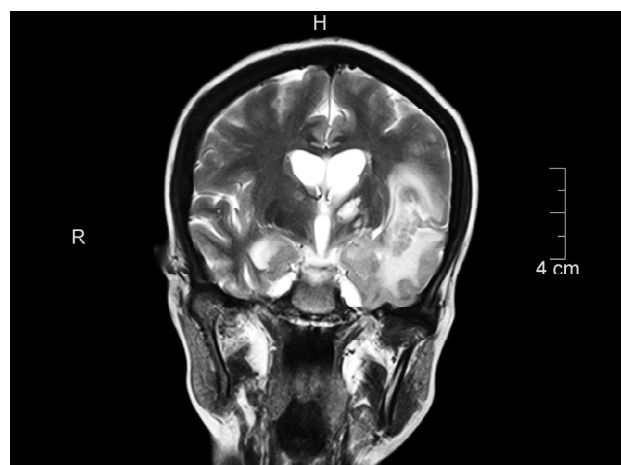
MRI brain coronal T2W image showing borderzone encephalitis in the region of left sylvian fissure
